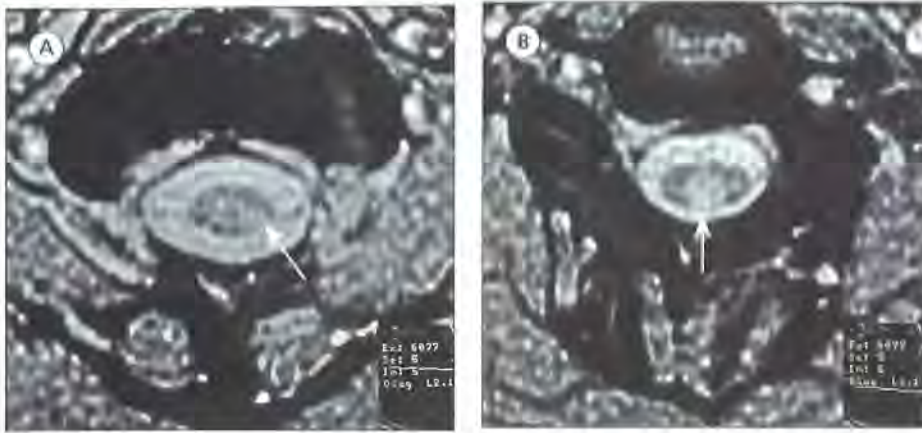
Multiple sclerosis. (A) and (B) T₂-weighted axial MRI scans through the spinal cord show two intrinsic lesions that involve only part of the cord cross-section and extend to the surface of the cord (arrows). Kindly provided by Dr Katherine Miszkiel.
